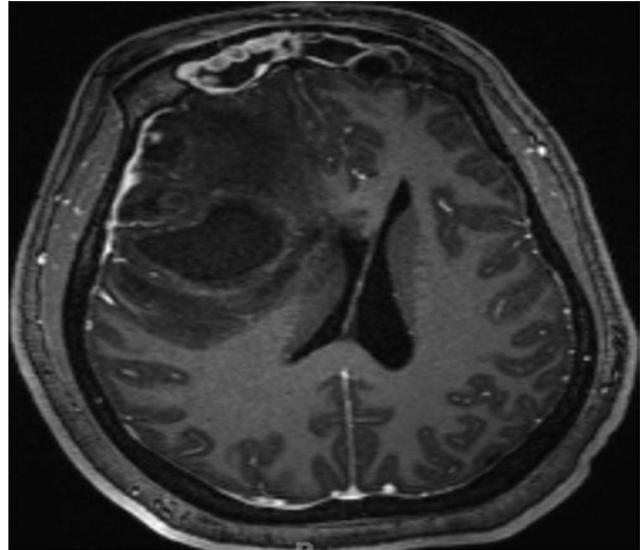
Axial T1-weighted MR imaging sequence with gadolinium administration showing a right frontal intraparenchymal abscess with additional findings of bilateral frontal sinusitis and abnormal contrast enhancement.
